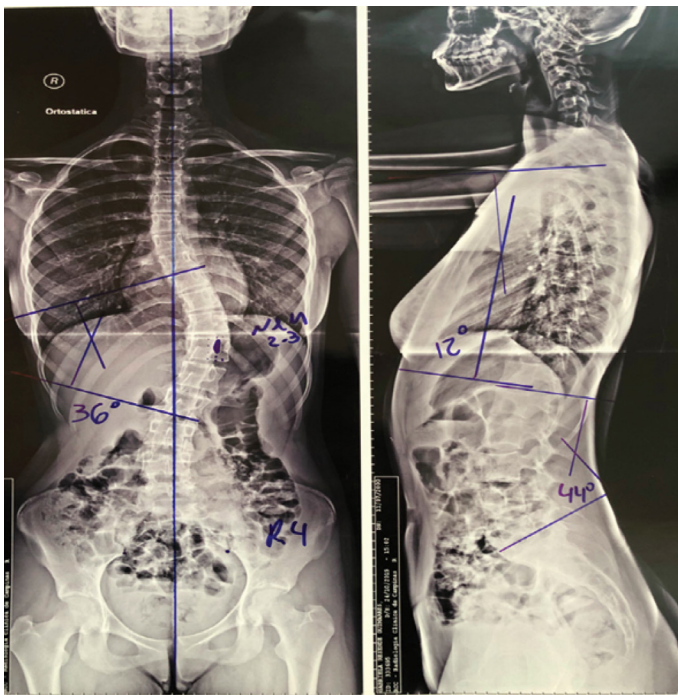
Representation of the sagittal angles of thoracic kyphosis and lumbar lordosis on the X-ray imaging of adolescents with idiopathic scoliosis.
